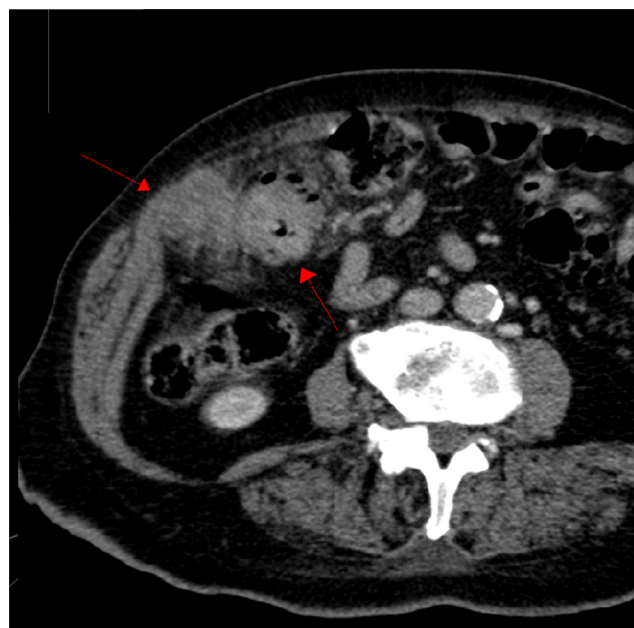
Computed tomography of the abdomen showed a liver angle lesion with local peritoneal infiltration and lymph node enlargement in the root of the middle colic artery.
